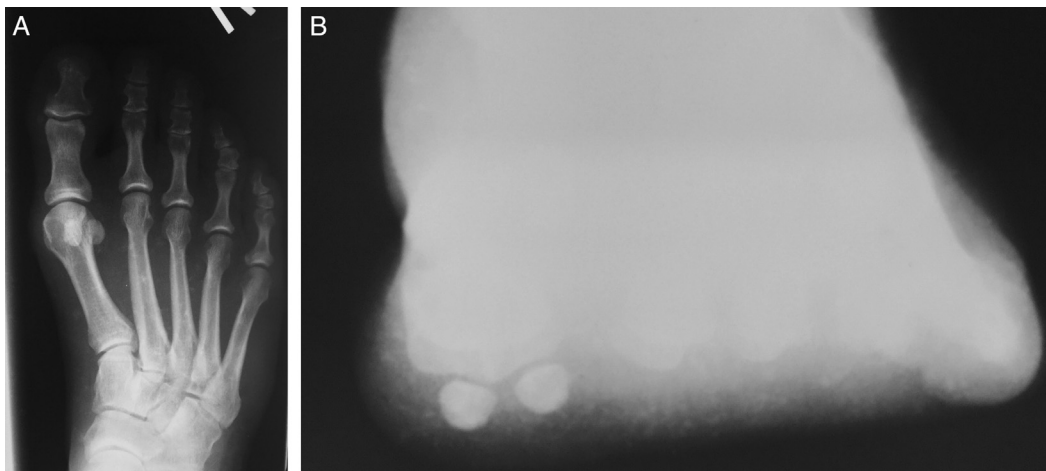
(A) Anteroposterior radiograph showing positive lateral round sign and tibial sesamoid position suggesting metatarsal eversion. Traditional evaluation of the tibial sesamoid position would suggest metatarsal subluxation off the sesamoids. (B) Semi-weightbearing sesamoid axial view showing sesamoids located normally, medially and laterally to the median crista. Eversion of the first metatarsal has altered the findings visualized and assessed on the anteroposterior projection.
